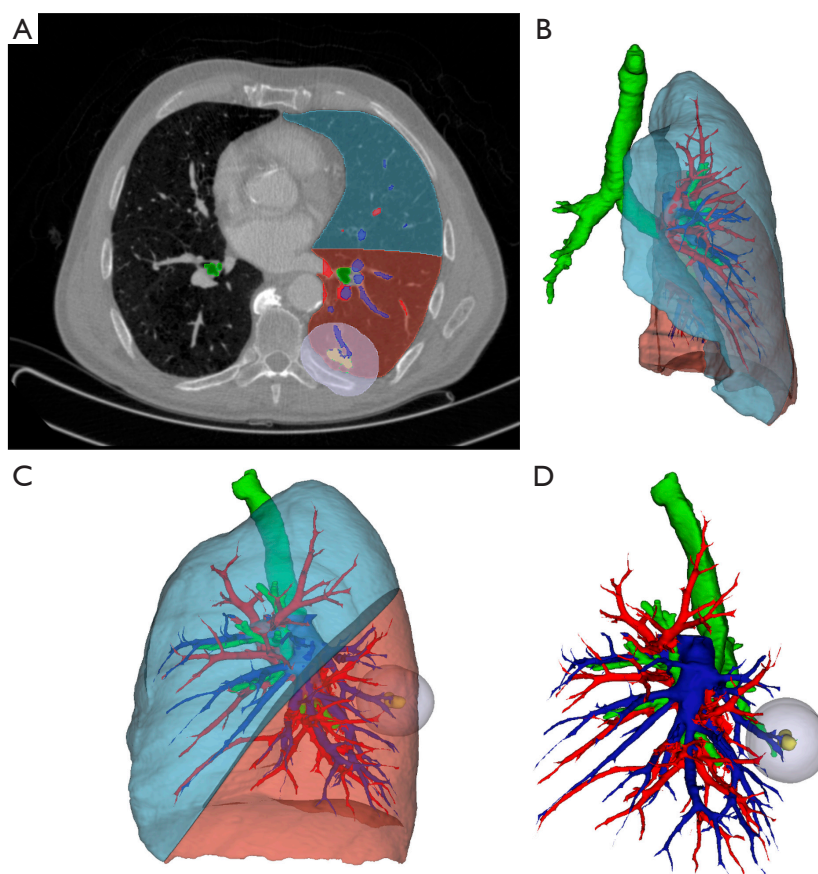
Preoperative 3D lung reconstruction of patient 6. Segmentations of the left upper lobe (transparent blue), left lower lobe (transparent red), airway (green), pulmonary arteries (blue), pulmonary veins (red), lung nodule (yellow), and surgical safety margin (transparent grey) were visualized in an axial slice of the CT scan (A), 3D view in the anterior direction (B), 3D view in the lateral direction (C), and 3D view in lateral direction without segmentations of the lobes (D). All elements in this figure are original. 3D, 3-dimensional; CT, computed tomography.
